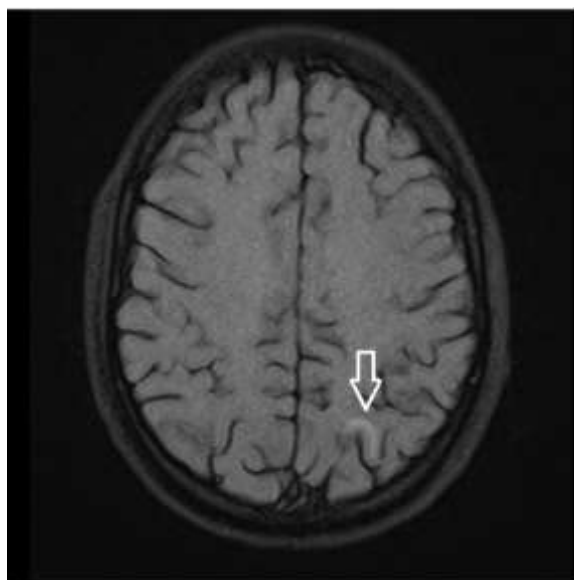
Increased signal intensity in the occipital lobe as indicated by an arrow on the MRI image
